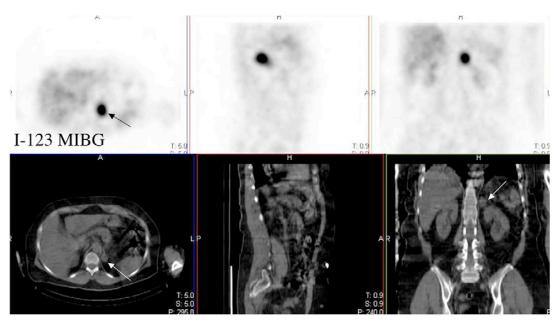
Single-photon emission computed tomography/computed tomography (CT) examination with I-123 metaiodobenzylguanidine (MIBG) from a patient with a left adrenal pheochromocytoma. Tumor is depicted by white arrows on CT and black arrow on MIBG images.
